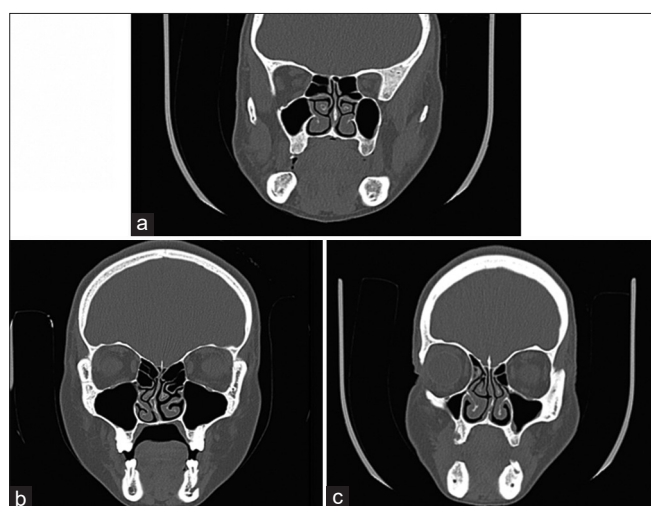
(a) Coronal computed tomography image showing nasal septum (red arrow) in midline, (b) Coronal computed tomography image showing deviated nasal septum (red arrow) toward left side, (c) Coronal computed tomography image showing deviated nasal septum (red arrow) toward right side
